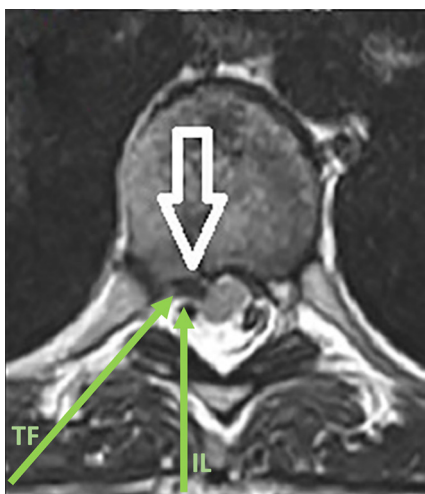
Possible approaches to case 2, adapted from Telfeian *et al.* (1). TF route and IL route to a right T8–9 herniated disc (white arrow) in an axial T2 MRI. TF, transforaminal; IL, interlaminar route; MRI, magnetic resonance imaging.
